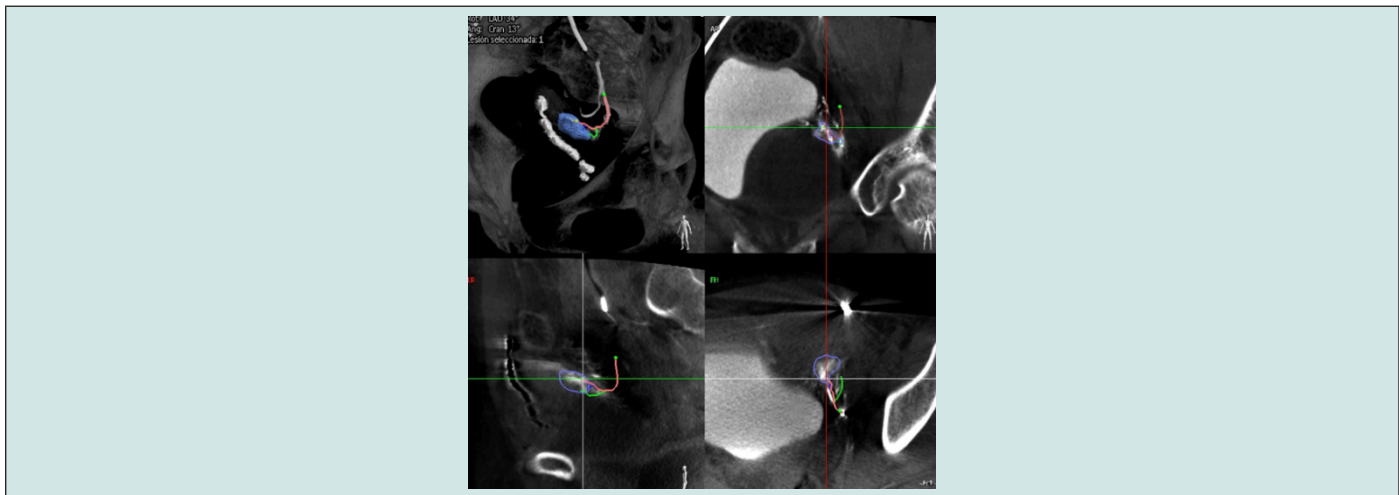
expert-CT tool after the cone-beam CT show us with colors the nutritional vessels of the tumor.
